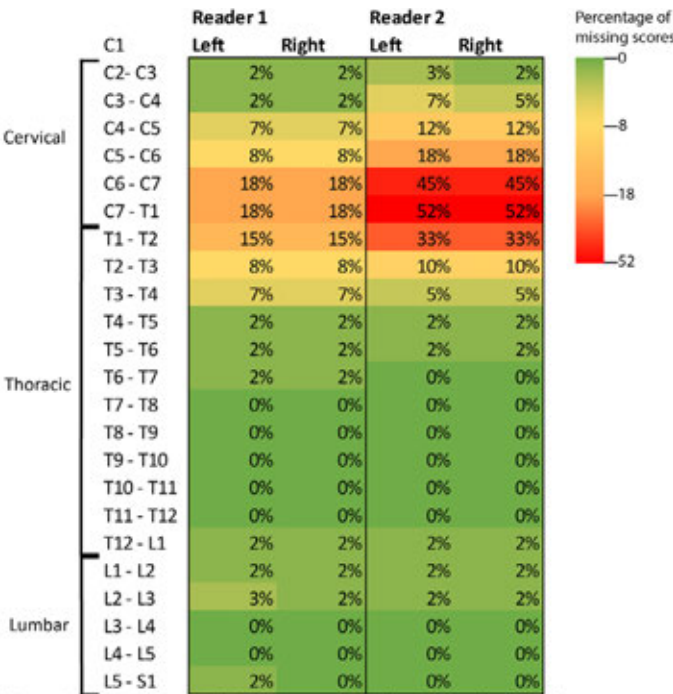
percentages of missing scores per reader on low dose CT of facet joint ankylosis, for the left and right joint.
